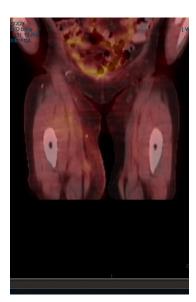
Response PET/CT scan 2 months after completion of treatment
